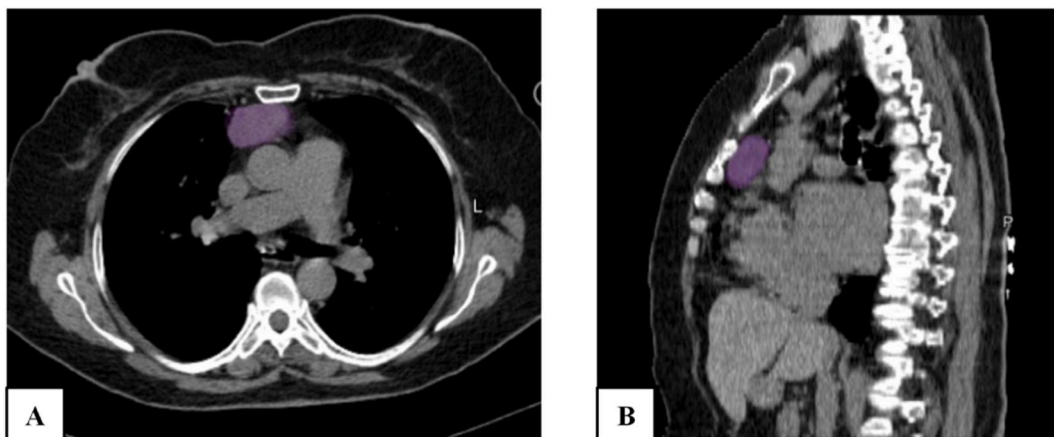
Chest CT scan A: oval-shaped, solid, hypodense anterior mediastinal mass, measuring about 4.1 × 3.1 × 2.2 cm with enlarged lymph node mostly representing thymoma. B: Sagittal section showing oval-shaped hypodense thymoma with the previously mentioned measures, with close relation to the mediastinal structures.
